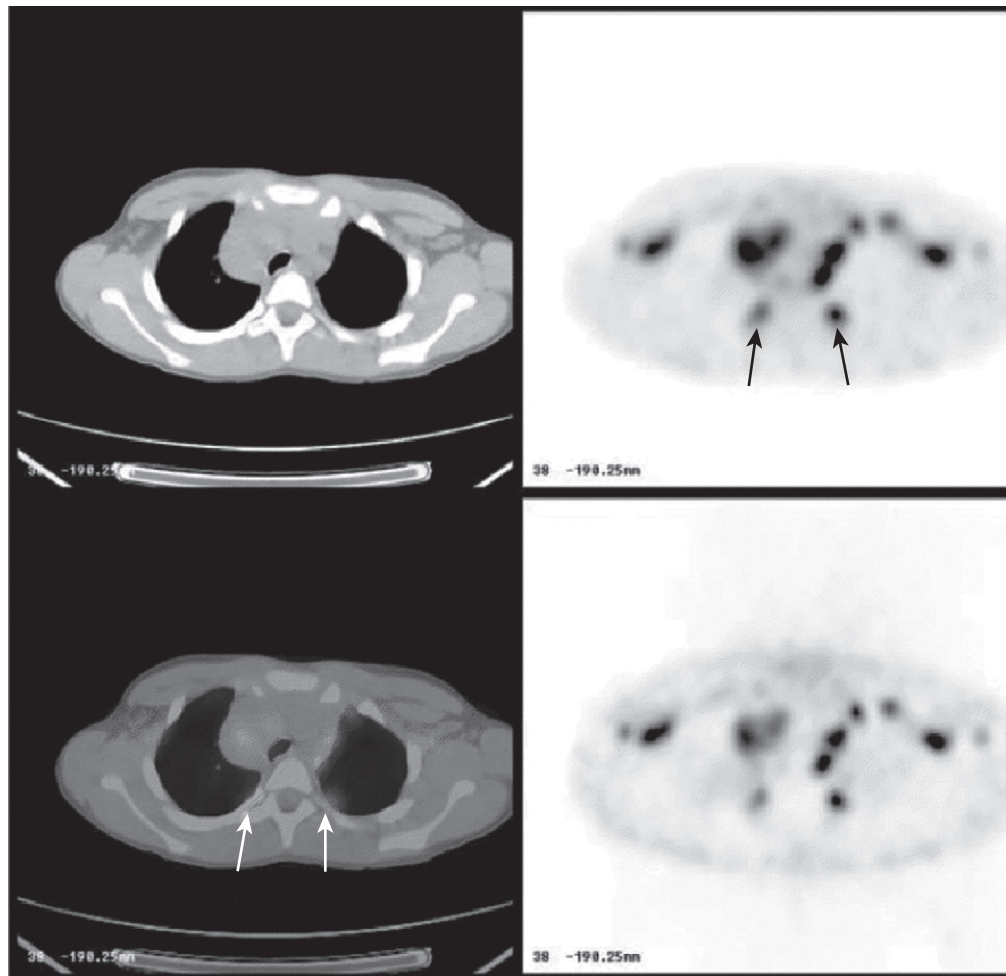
Combined positron emission tomography (PET)-CT images (axial) through the upper chest of a 7-year-old girl with a mediastinal mass found to be a necrotizing granuloma. Multiple sites of 2-deoxy-2-(18)F-fluoro-D-deoxyglucose (FDG)-avid axillary lymph nodes and multiple foci within the mediastinal mass are visualized. Arrows highlight the symmetric avidity of the costovertebral junctions for FDG that can be seen in children. (From Kaste SC: Issues specific to implementing PET-CT for pediatric oncology: What we have learned along the way? *Pediatr Radiol* 2004;34:205-213.)
